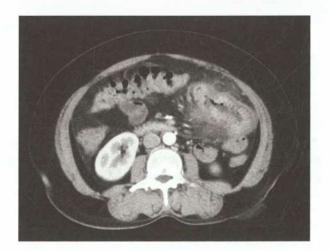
Jejunal carcinoma—CT coronal section
